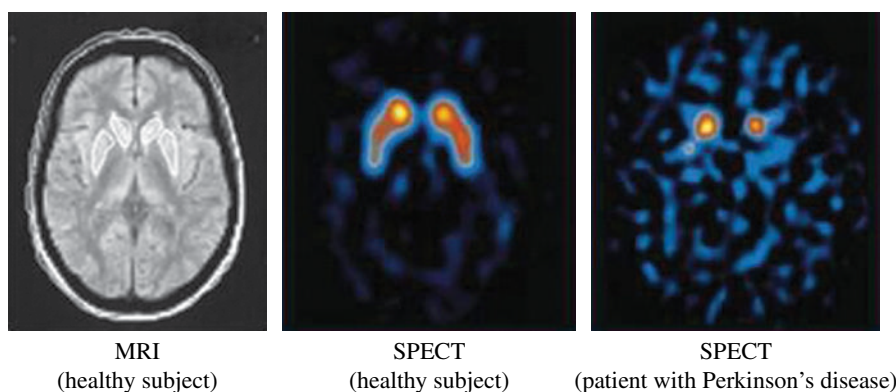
MRI and SPECT images of the human brain obtained with Ioflupane [^{123}I] (cross-section of the brain). Left: MRI image of the brain in a healthy subject, in which the striata are visualized as two white “comma-like” images that are symmetrically located near the center of the brain. Middle: SPECT image of the brain in a healthy subject, in which the striata are visualized as two red-yellow “comma-like” images as with MRI. Right: SPECT image of the brain of a Parkinson's disease patient, in which the radioactivity accumulation in the putamen (bottom part) of the striata disappears, and only the caudate nucleus (upper part) is visualized in the shape of a “full-stop.” When the disease further progresses, the radioactivity accumulation in the caudate nucleus also disappears.
